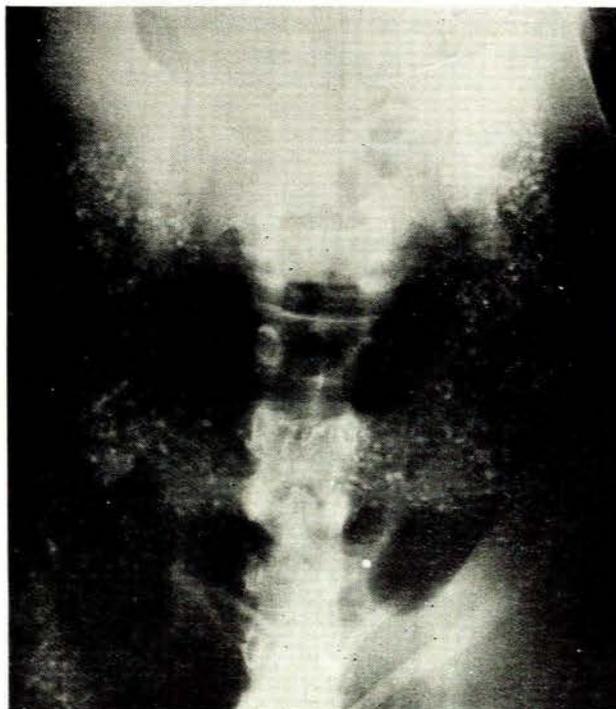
Plain radiograph of the abdomen of a woman with iron deficiency anaemia who stated that she consumed at least a cupful of earth a day. Radio-opaque material is visible within the bowel.
